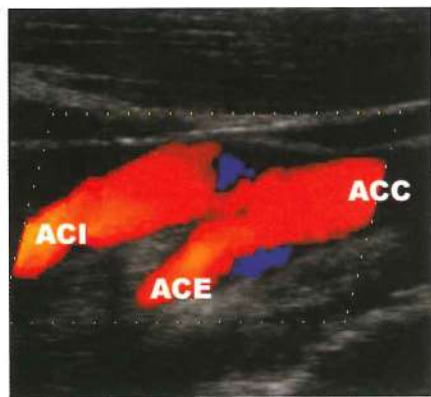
Normal appearance of the carotid bifurcation on Color Doppler (Duplex) Flow Imaging.
